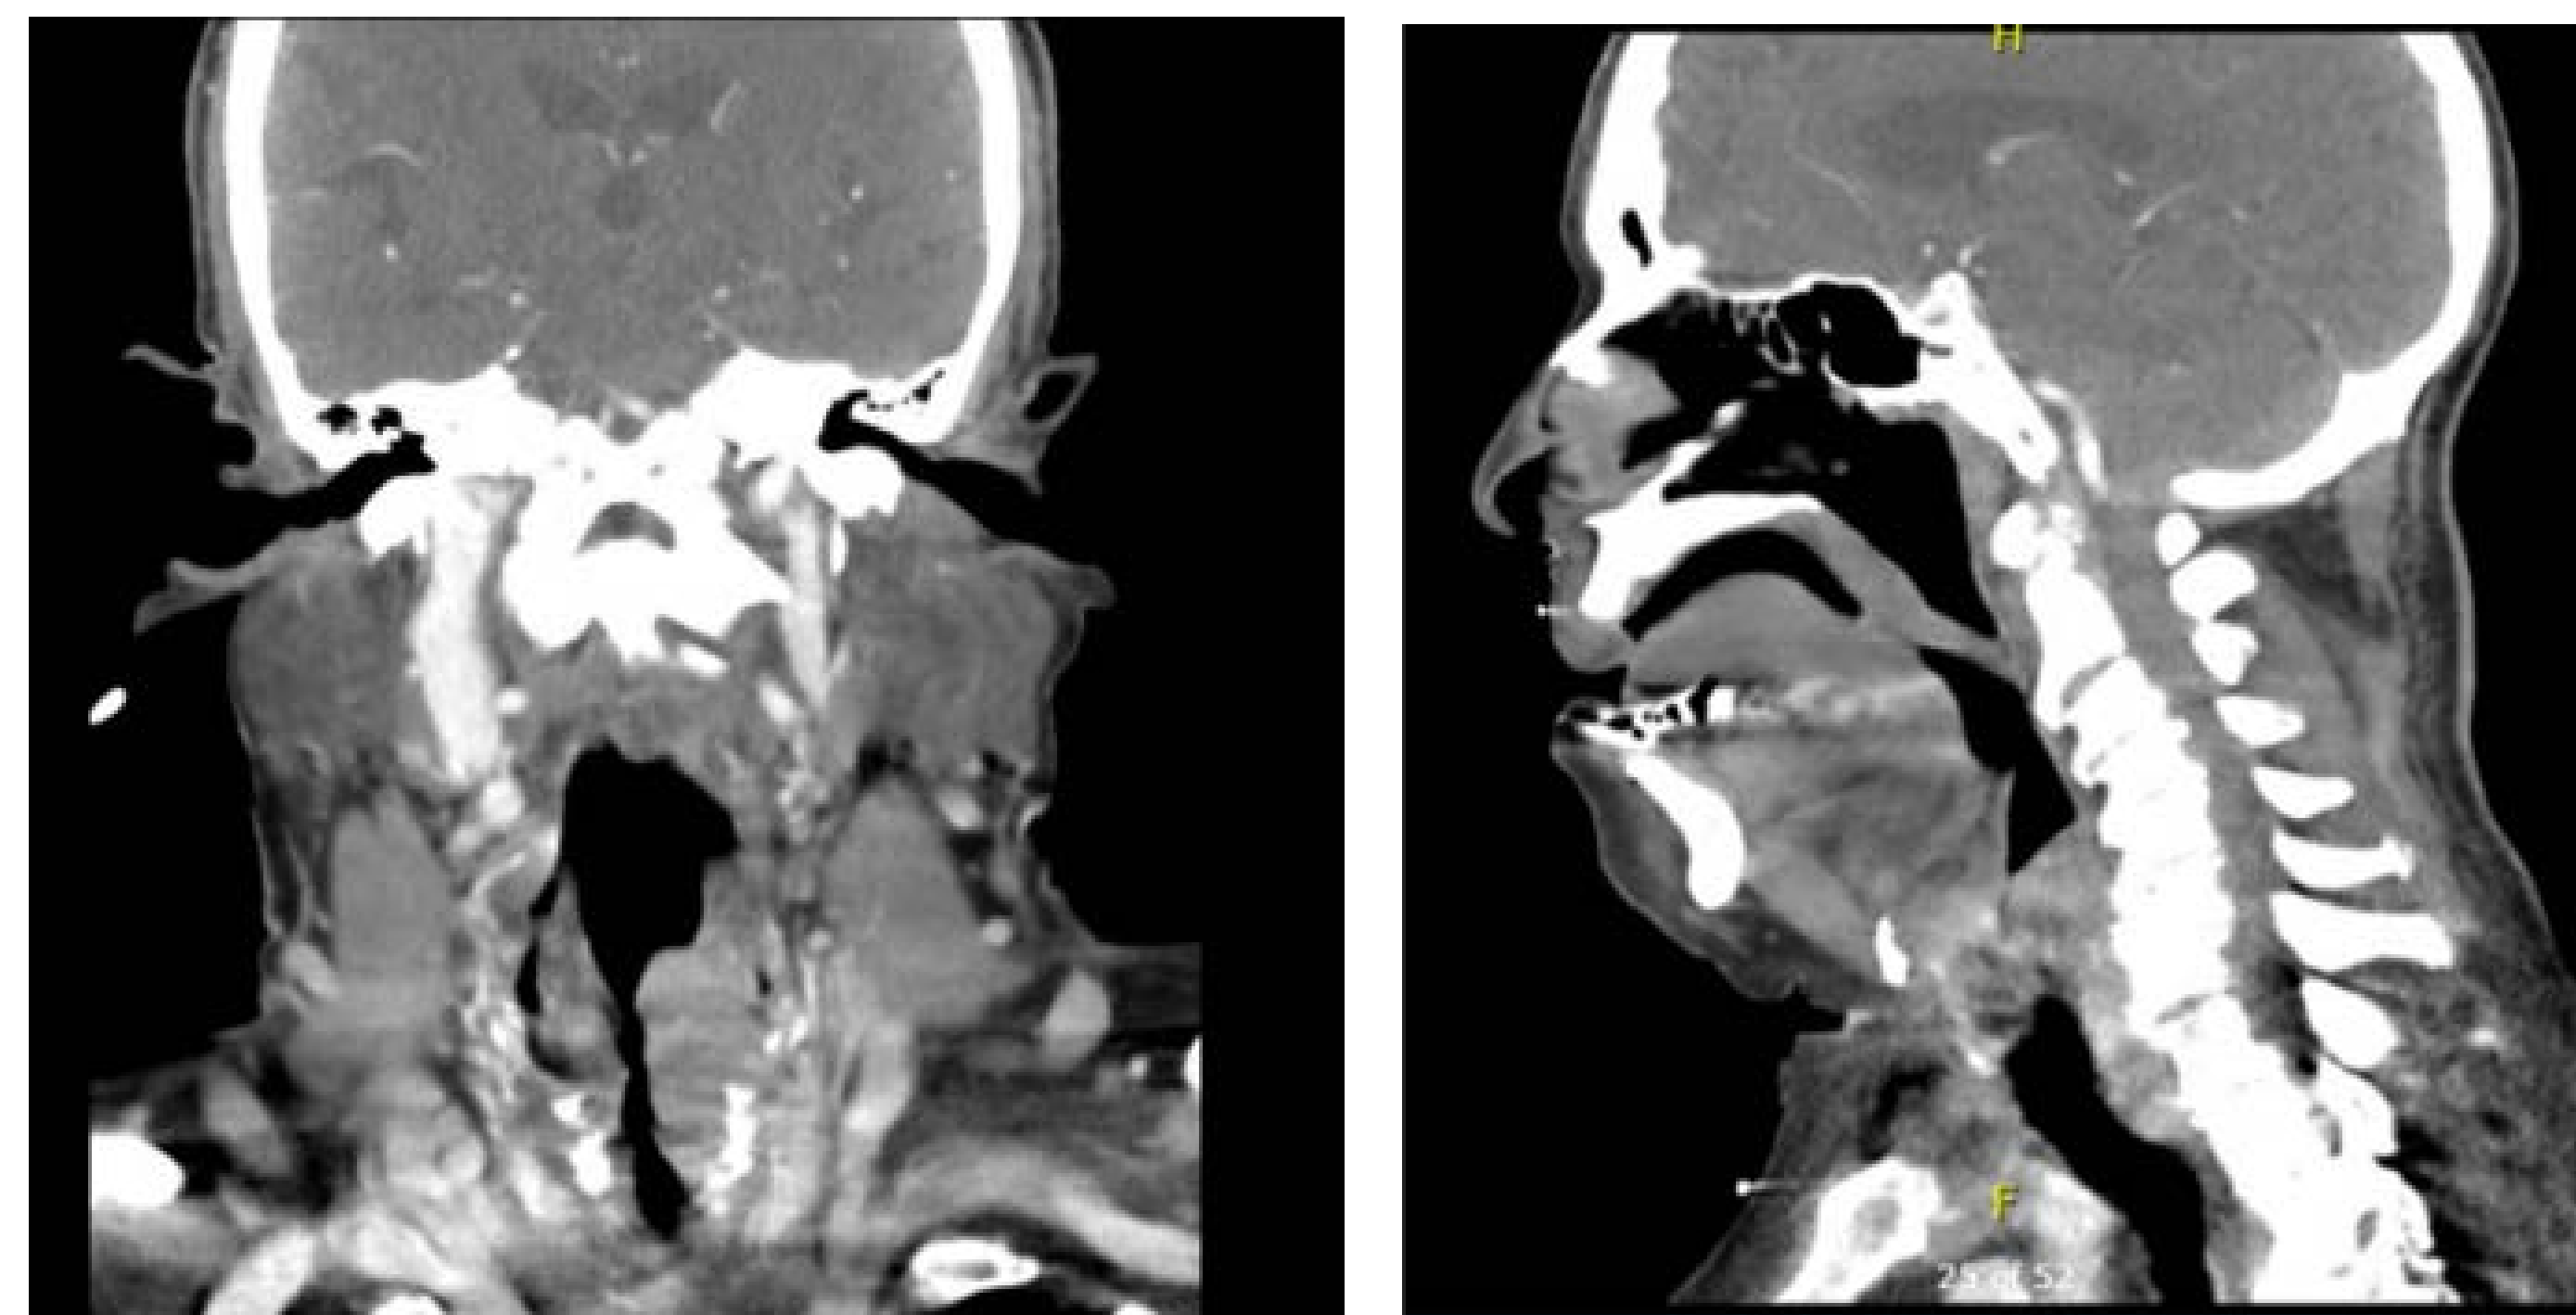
Coronal and Sagittal CT Neck with contrast demonstrating mass extending from left wall of the larynx with partial obstruction of the airway
